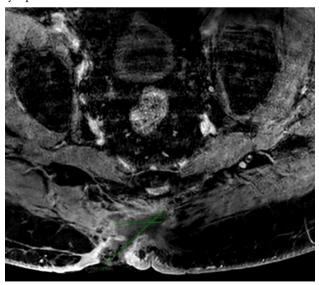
MRI for staging of local involvement. Muscle plane, prevertebral fascia, and skin are compromised.
